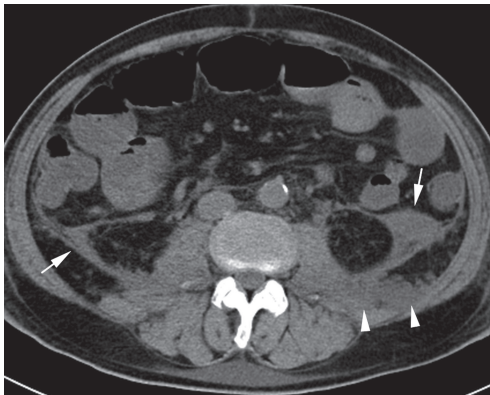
A 49-year-old woman with acute pancreatitis (retroperitoneal extension grade V). Unenhanced CT shows extensive bilateral retroperitoneal inflammatory changes due to acute pancreatitis (arrows) with extension to the left posterior pararenal space (arrowheads), representing the highest grade of retroperitoneal extension (Grade V).
